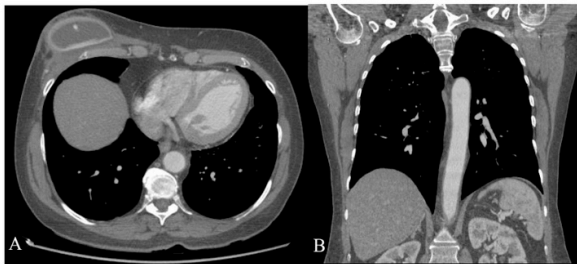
CT of the chest with contrast 255 days after the onset of symptoms, demonstrating a reduction in the concentric parietal thickening of the aortic segments (more evident at the level of the arch, with a slight extension to the emergence of the supra-aortic branches, and in the descending portion), with parietal thickness maximum of 0.3 cm (previously 0.6 cm). A. Axial section. B. Coronal section.
